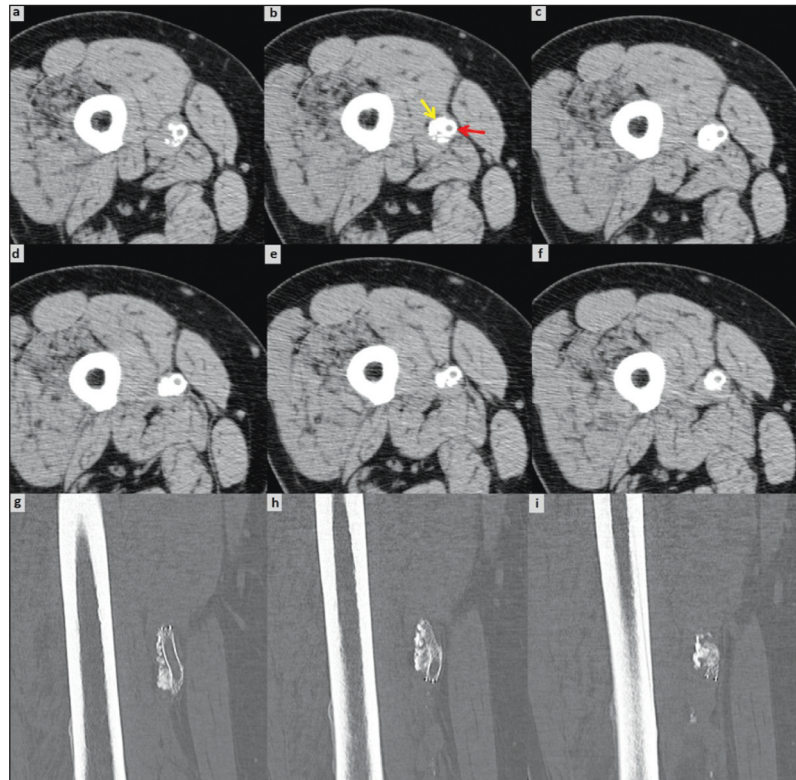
Consecutive axial plane computed tomography images (a-f) and reformatted coronal images (g-i) of the femur. Perivascular soft tissue calcification (left yellow arrow) was observed on the lateral side of the superficial femoral artery stent (right red arrow) (b). Coronal computed tomography images showed the indentation of the stent clearly.
